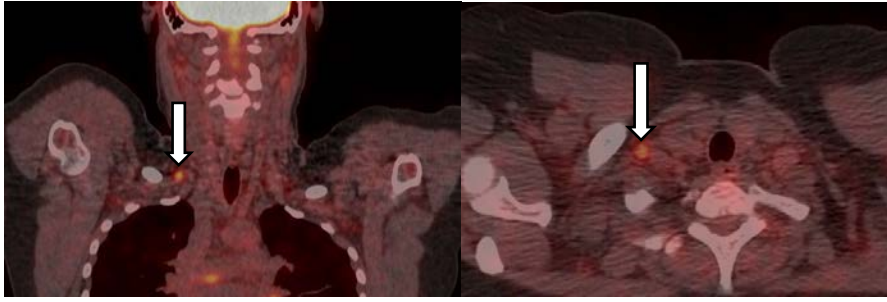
A 32-year-old with TNBC with suspicious right supraclavicular node on FDG PET/CT. SUV_{max} Primary disease 24.7, Supraclavicular node 3.5. Biopsy results were negative for malignancy.
